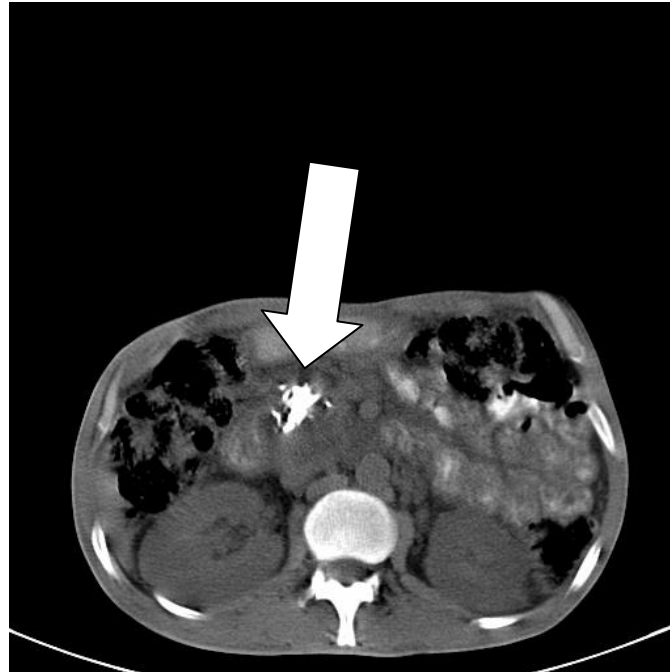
FIGURE # 2 : PLAIN CT ABDOMEN AXIAL SECTION SHOWING CALCIFICATIONS IN PANCREATIC TAIL (ARROW).
